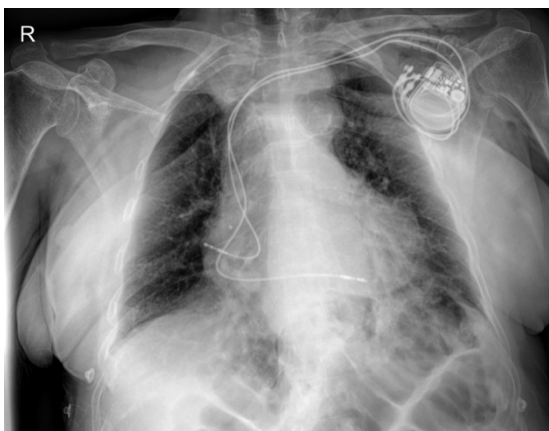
The absence of pneumothorax signs in lung x-ray. PM is seen in the left upper chest region.
